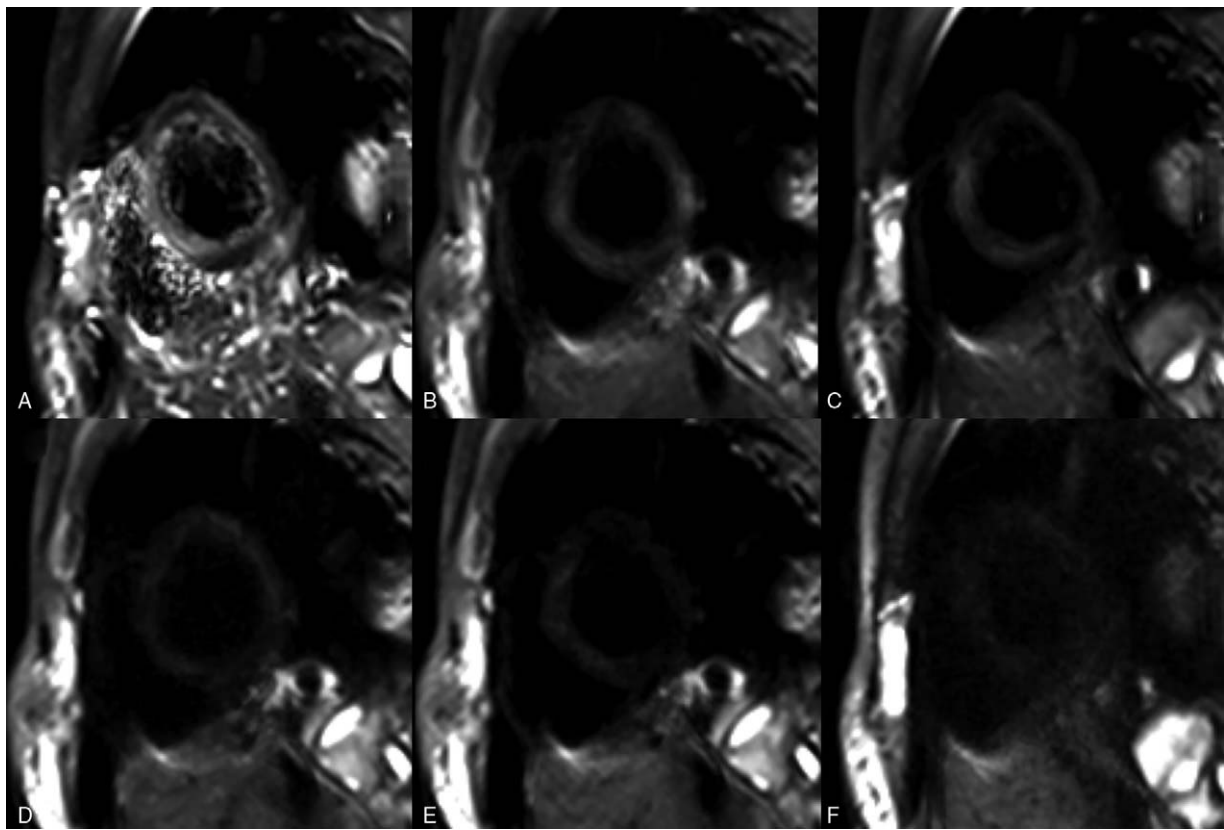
Short axis multi-b-value DWI images of the heart, revealing uniform signals of the myocardium in the left ventricle. No artifacts were found, and the signal of the myocardium decreased with the increase in b-value.
